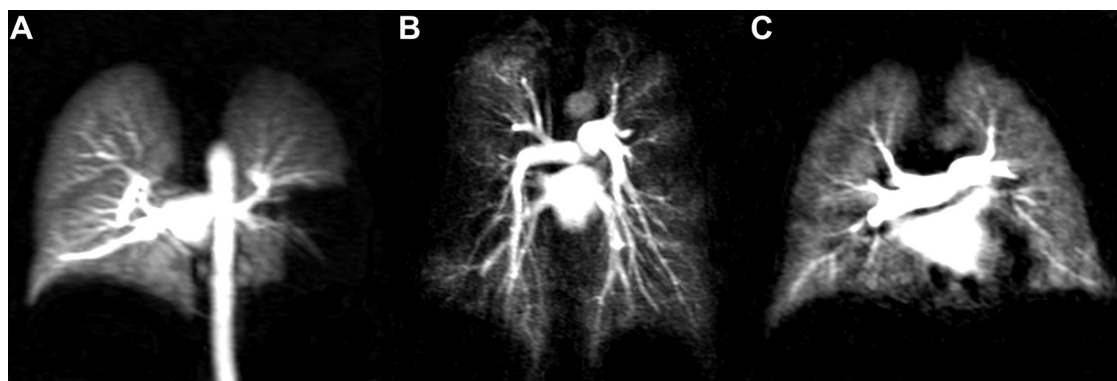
A: occlusion of pulmonary vessels will lead to sharply delineated perfusion defects as in this case of acute pulmonary embolism of the left inferior lobe in the pulmonary perfusion MRI [maximum intensity projection (MIP) image]. Perfusion of the right lung remains unimpeded. B: in contrast, cystic fibrosis with its extensive mucus obstruction of airways goes along with large hypoperfused areas in both lungs (MIP). C: chronic obstructive pulmonary disease COPD with concomitant emphysema shows a generally lower degree of contrast enhancement as well as diffuse patchy perfusion defects predominantly of the superior lobes (MIP).
